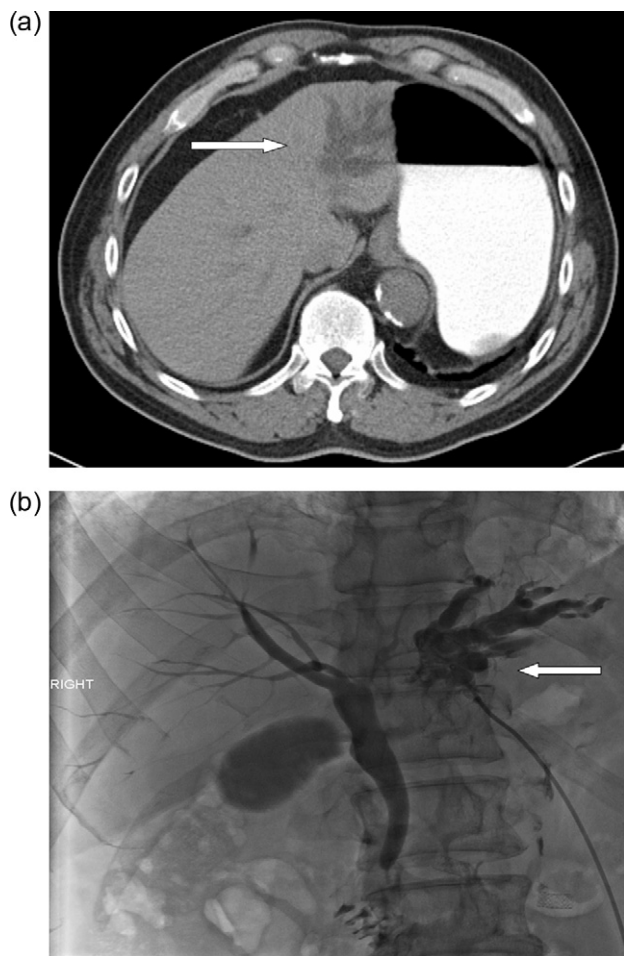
(a) Imaging–CT scan showing dilated ducts. (b) Imaging–cholangiogram showing dilated ducts.
